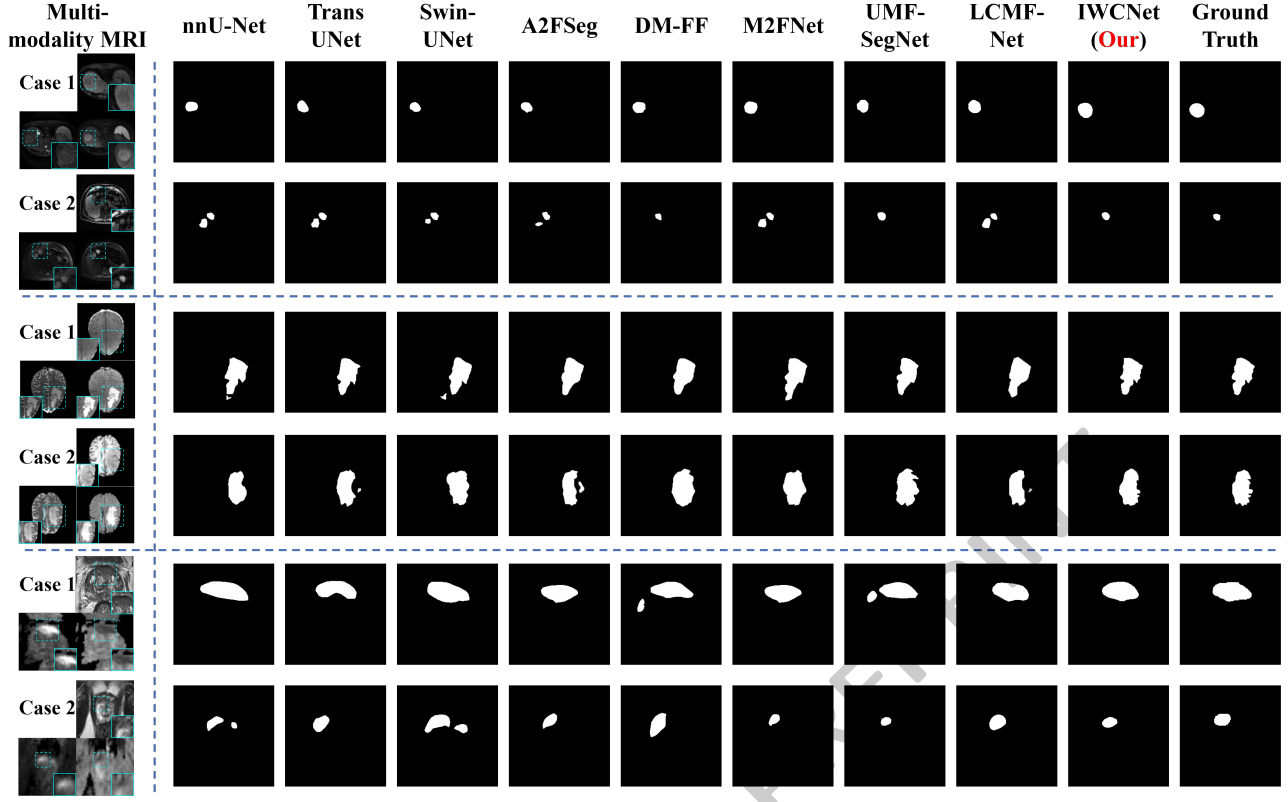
Our IWCNet accurately segments lesions from multi-modality MR images and outperforms all eight comparative methods across the liver, brain, and prostate datasets. Case 1 and Case 2 are from two different external test centers.
